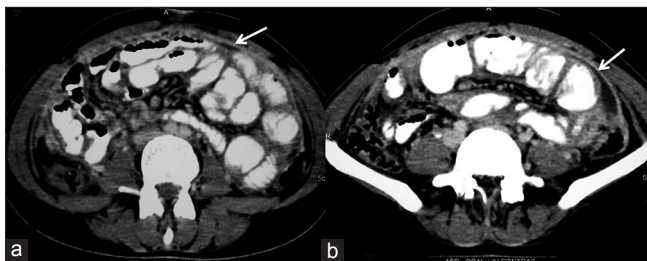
Abdominal cocoon in 40-year-old male due to previous abdominal surgery (a, b) axial contrast-enhanced computed tomography showing enhancing membrane (arrows) and focal dilatation of jejunal loop
